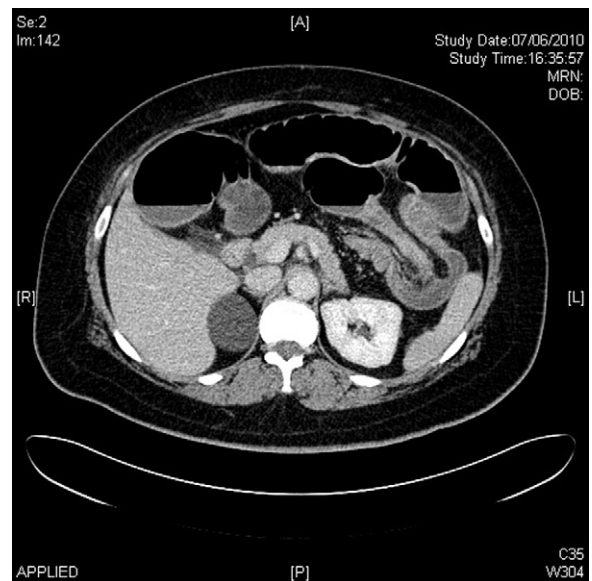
Axial CT scan of colo-colonic intussusception secondary to lipoma.
